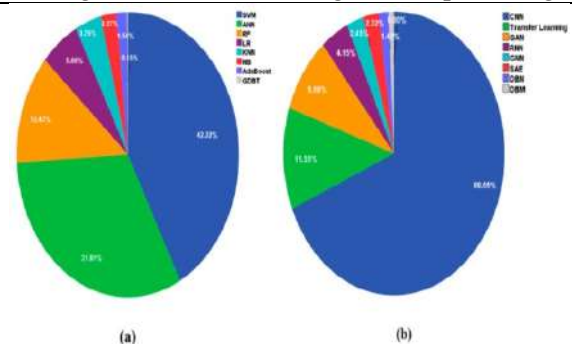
Utilization of Various AI Models for MRI Data Analysis.
